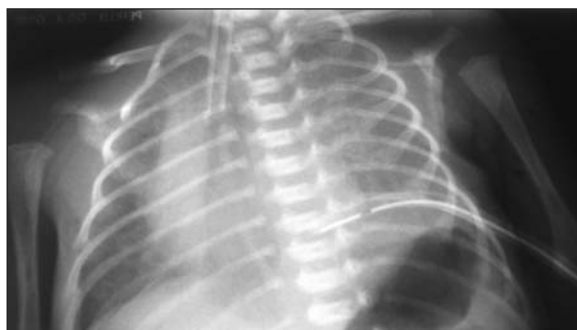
Chest X-ray showed a large amount of fluid in the left pleural space and a slight mediastinal shift and a chest tube was placed to drain the hydrothorax.
